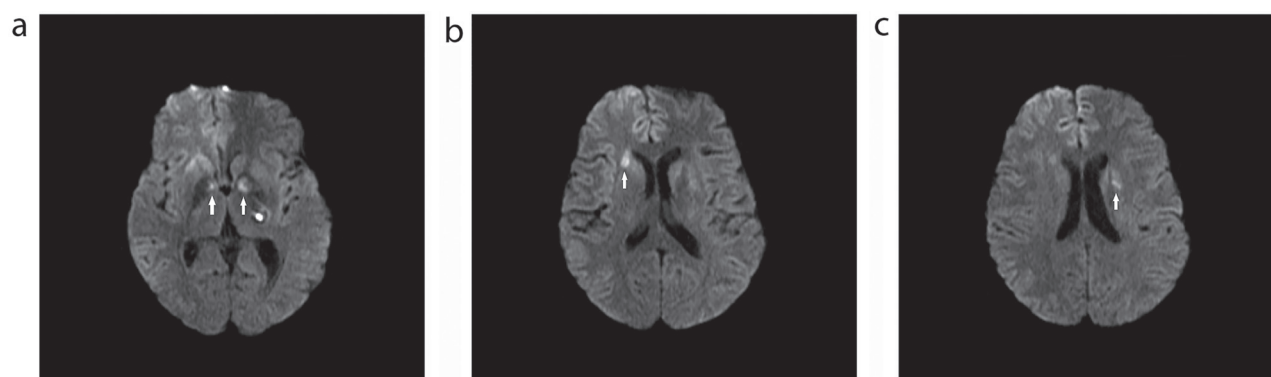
a-c. (a) Axial diffusion-weighted MRI scan 2 weeks after second admission, showing two new lesions with high signal intensity in the genu of the internal capsule bilaterally (arrows), (b) A third lesion is depicted in front of the right caudate nucleus (arrow), (c) Another new lesion is depicted periventricularly, laterally to the left lateral ventricle (arrow).
